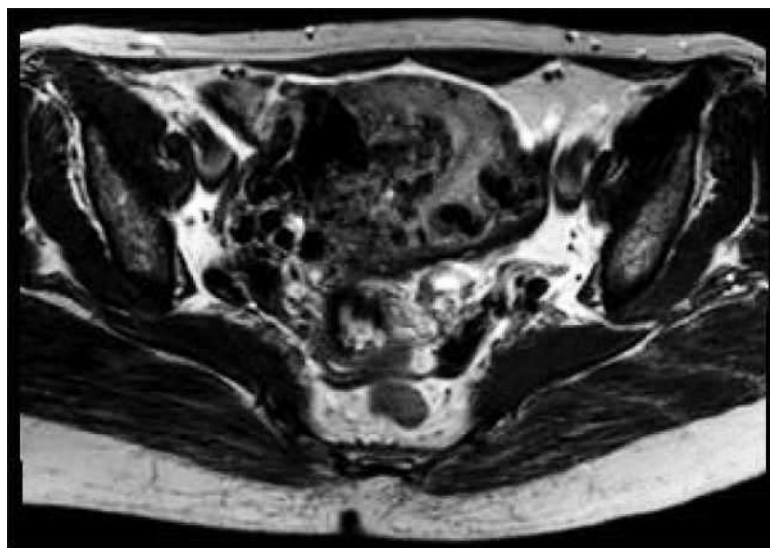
T2-weighted magnetic resonance image depicting a uterine arteriovenous malformation with extensive areas of signal void in the myometrium and serosal layer.
